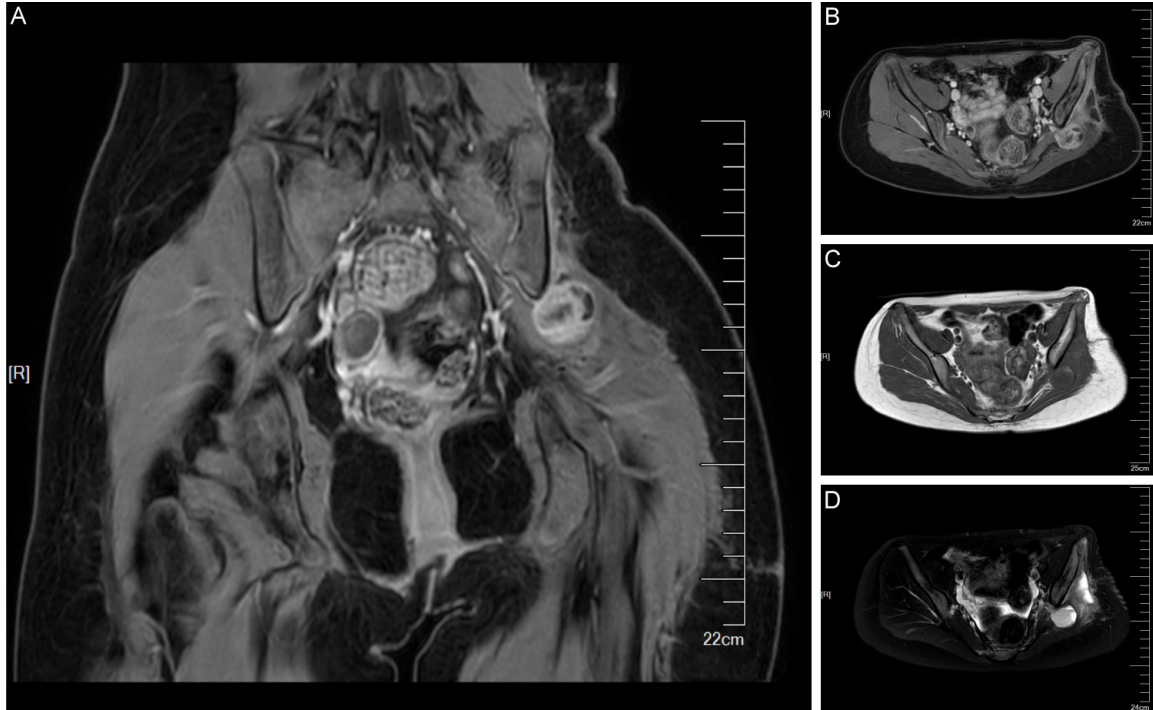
Pelvic MRI after adjuvant chemotherapy revealed a nodular mass, approximately 32 × 25 mm in size, located between the deep surface of the gluteal muscle and the piriformis muscle in the left buttock. The mass has unclear boundaries and shows no invasion of the left iliac bone. T2-weighted imaging with fat suppression is presented in (A) coronal and (B) transverse views. (C) T1-weighted imaging is presented in transverse views. (D) The enhancement sequence is also included.
